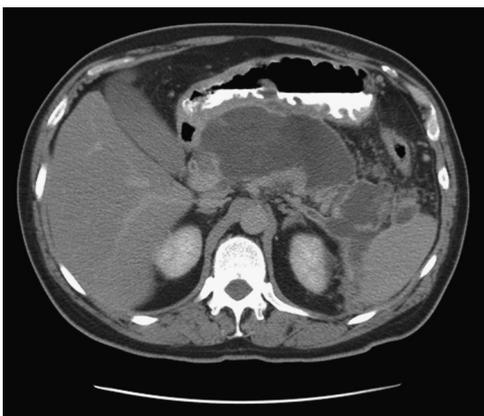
A CT scan revealing a large area of walled-off pancreatic necrosis indenting the posterior wall of the stomach and extending into the left retroperitoneum. See text regarding case 7 for clinical presentation and consensus management.
